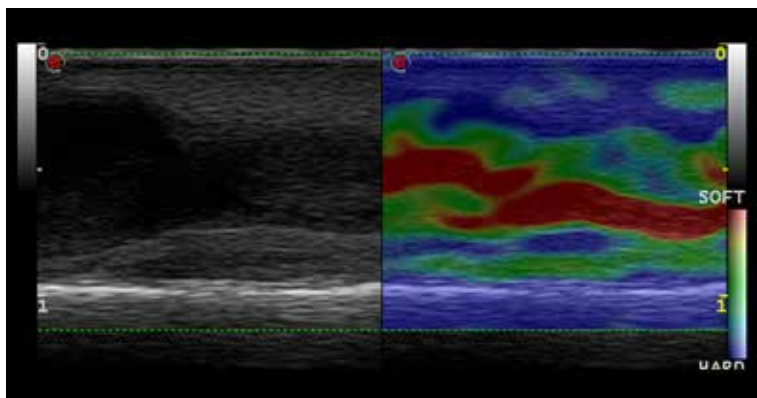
Follow-up ultrasound examination 7 days after detection of the thrombus. B-mode ultrasound image showing hypoechoic thrombus (left). US elastogram presenting a thrombus with a red area in the middle and green area peripherally (intermediate elasticity) (right).
